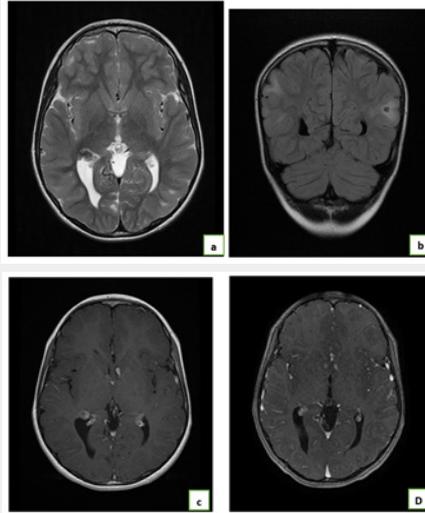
Brain MRI showing multiple nodules under heterogenic T2 signal ependymal(a)are enhanced after injection of gadolinium (cc ne T2 (and d)associated with cortical signal abnormalities in ranges, triangular in hypo signal T1, hypersignal T2 and FLAIR (bb),not enhanced after injection of gadolinium, in relation to cortical tubers re-entering the context of a STB.
